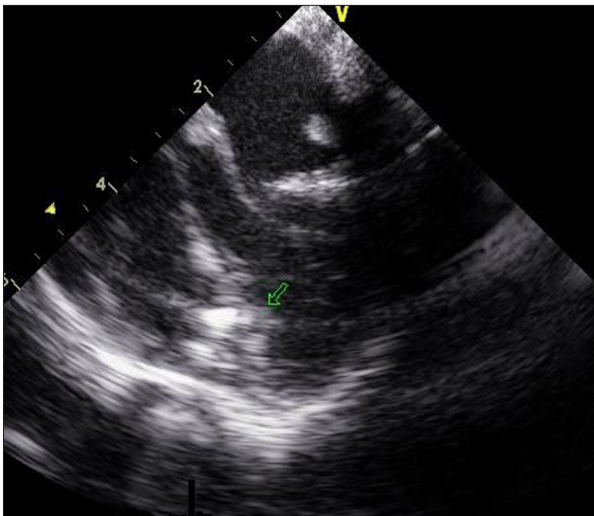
The guiding wire is passed through the muscular ventricular septal defect – intraoperative transoesophageal echocardiography (TEE) image.
